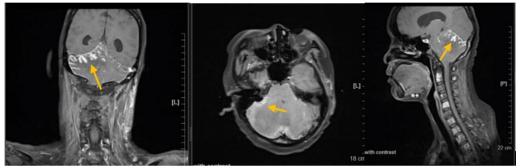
Nasopharynx MRI shows enhancement at leptomeningeal of right-left cerebellum hemisphere (*left to right: Coronal cut, axial cut, sagital cut*)
